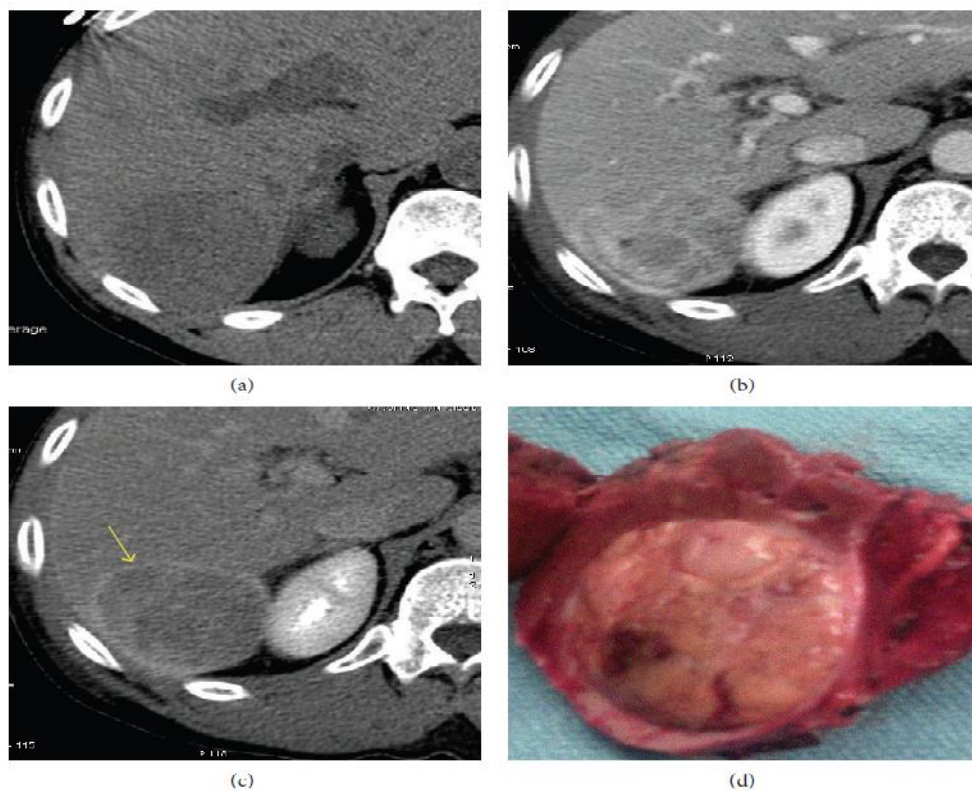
Solitary HCC. Axial CT images of the right hepatic lobe during precontrast (a), postcontrast venous (b), and delayed (c) phases show a well-defined heterogeneous solid enhancing mass occupying hepatic segment 7. Note the delayed enhancement of the lesion capsule.
